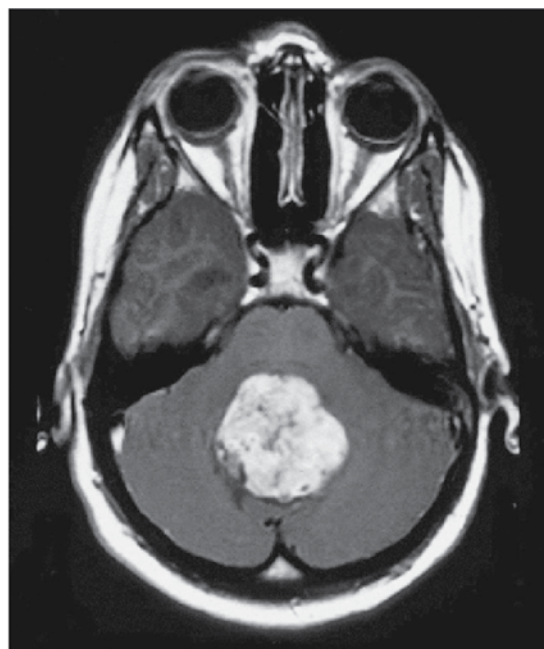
Medulloblastoma with typical location within the posterior fossa in an 8-year-old boy. Axial MRI, T1 weighted Gadolinium contrast enhancement.
